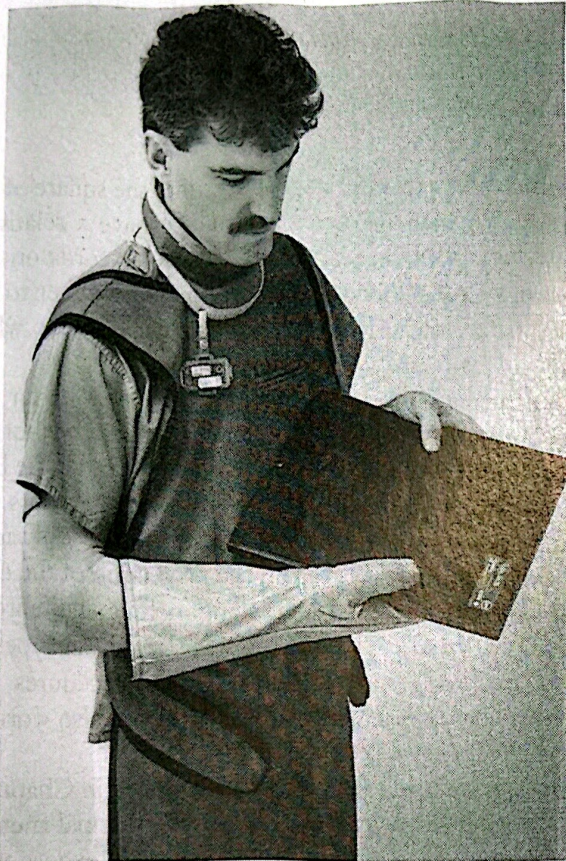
Limited operator wears protective apparel while holding a patient or during mobile radiographic examinations. Note radiation badge worn outside the apron at the collar.
